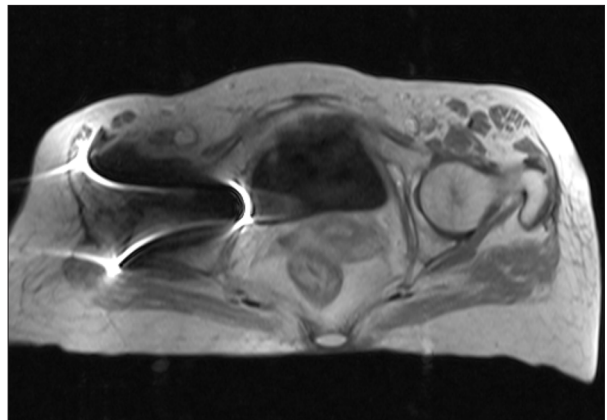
MRI showing uterine lesion with loss of fat planes between uterus and rectum.
